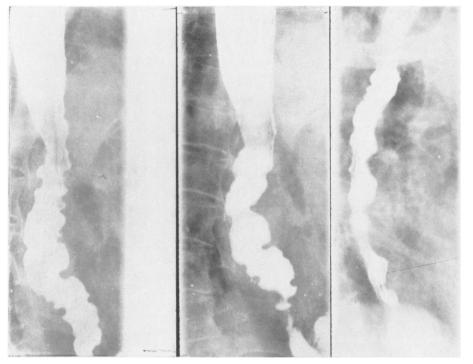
The oesophageal radiographs seen in three asymptomatic individuals. These are representative of asymptomatic diffuse spasm.
